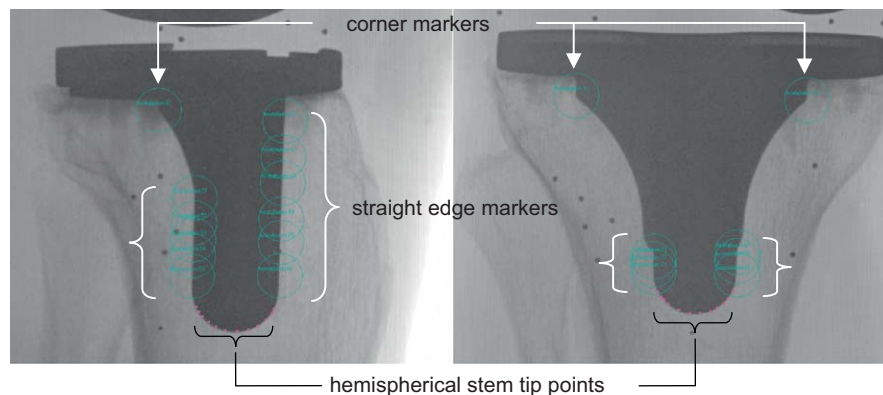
Landmarks of the implant used to define the implant-based coordinate system identified on the stereo x-rays in the RSA software. Corners are identified by adding markers; the software matches the correct corner marker in the anterior–posterior view with the visible corner marker in the medial–lateral view. The straight edges are identified by placing a series of markers along the edges. The stem tip centre requires the user to add points along the periphery, which are used by the software to calculate the centre of a sphere.
